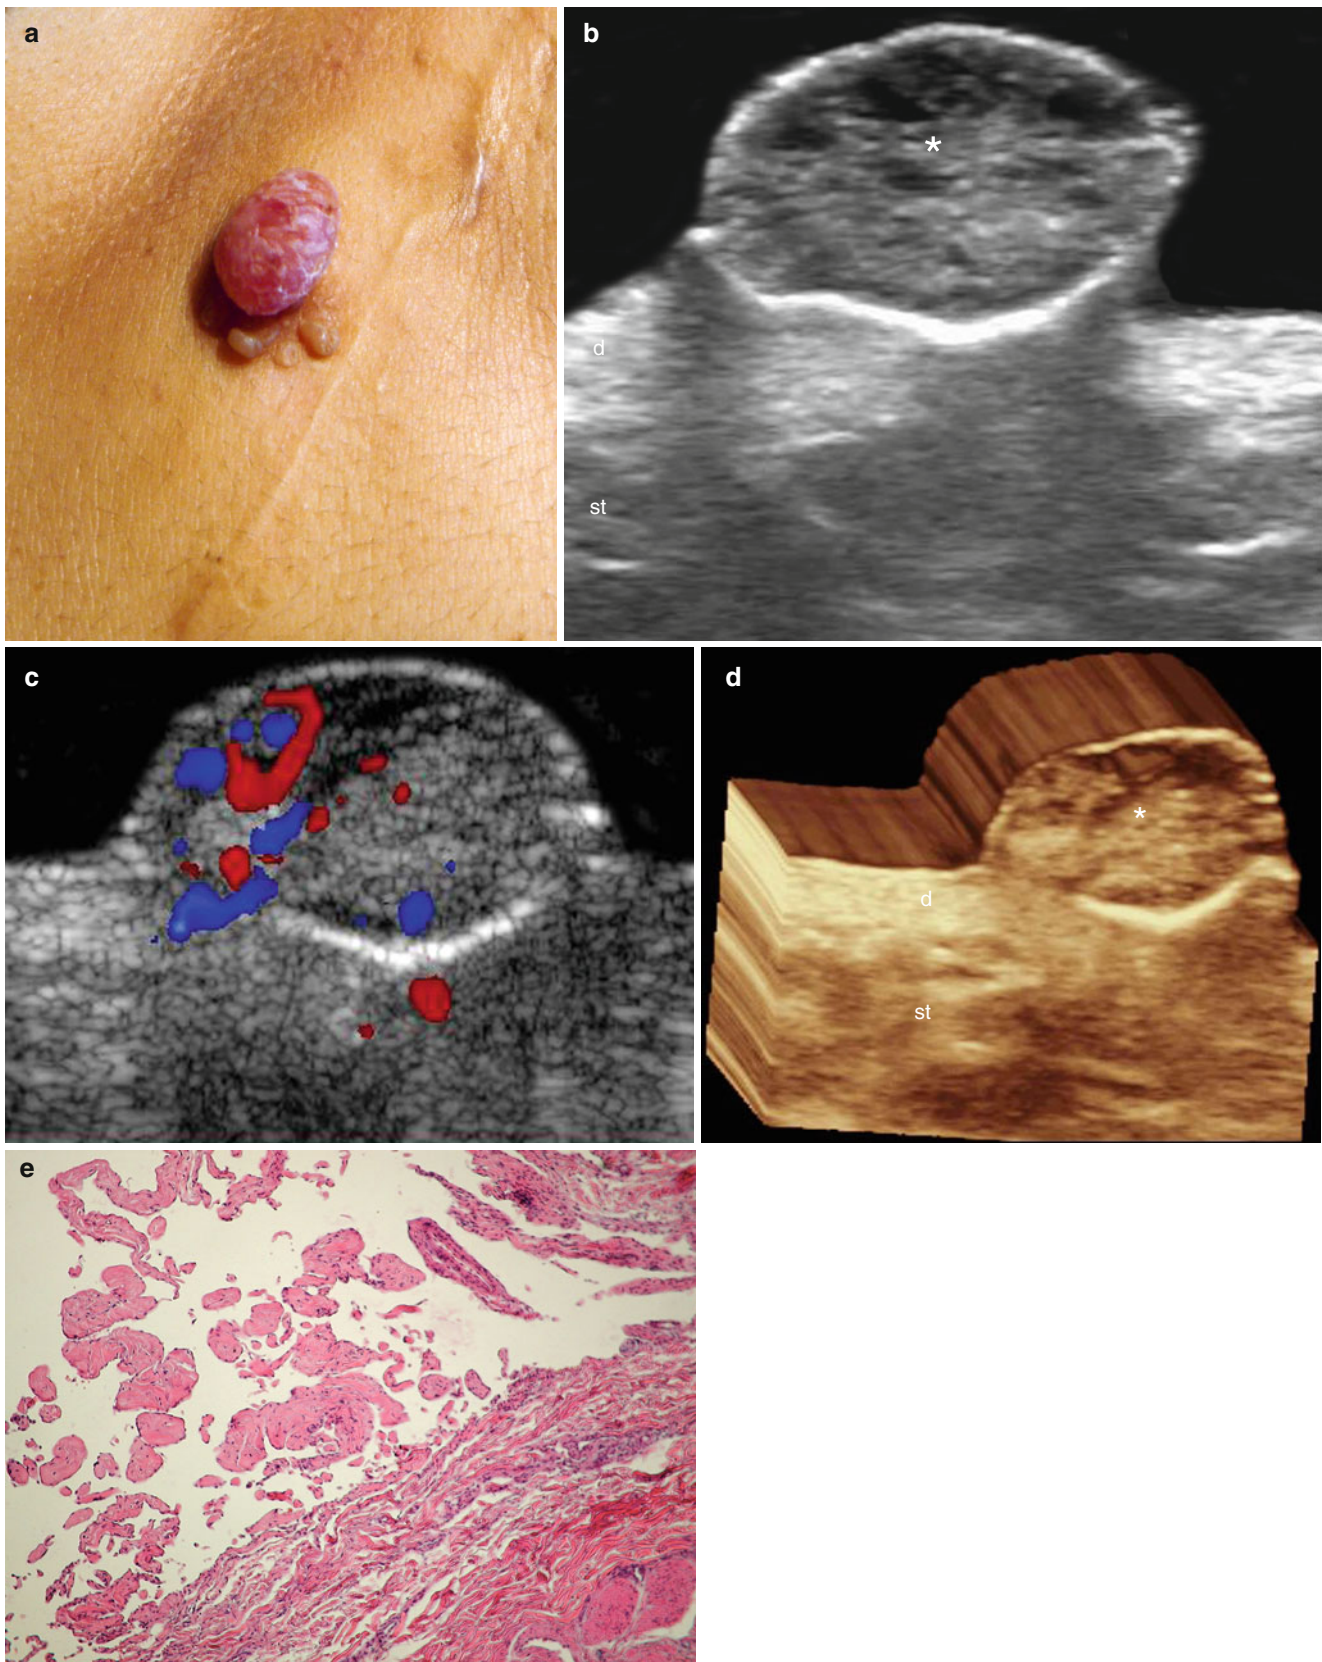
(a–e) Recurrent lymphangioma circumscriptum. (a) Clinical image shows erythematous and translucent cutaneous lumps and papules that recurred 2 years after surgery. (b) Grey scale ultrasound (transverse view in the large nodule) shows a well-defined mixed echogenicity oval-shaped nodule with anechoic and hypoechoic areas that emerges from the dermis and protrudes into the epidermal region. (c) Color
